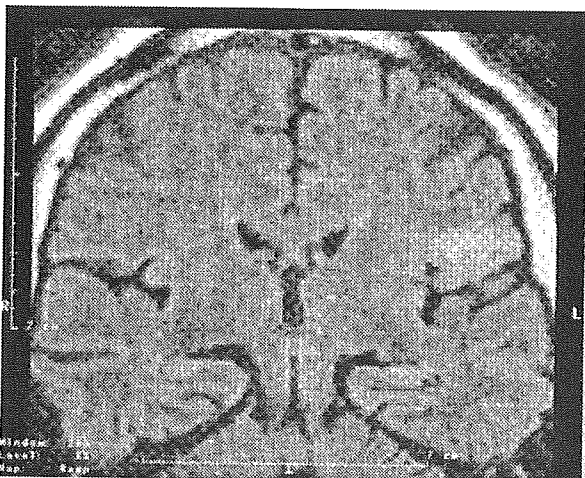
Coronal fluid-attenuated inversion recovery magnetic resonance imaging acquisition of patient 7. Note focal area of increased corticosubcortical signal in the left anterior frontoinsula region, compatible with a dysplastic lesion.
